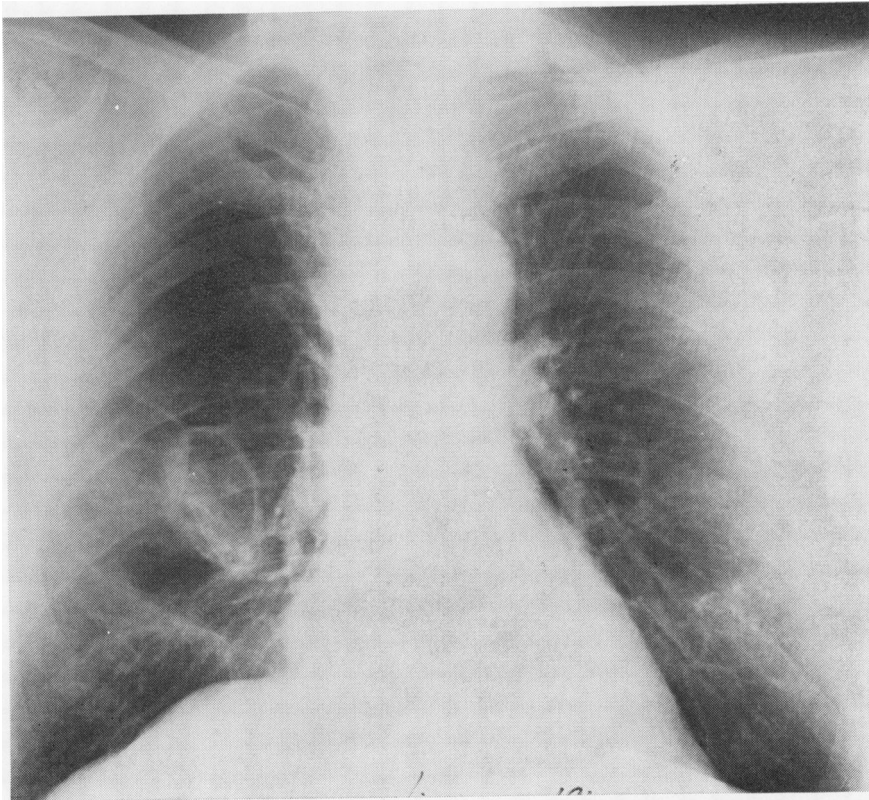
Chest radiograph showing a cyst-like lesion in the right lung. Same patient as fig 1.
